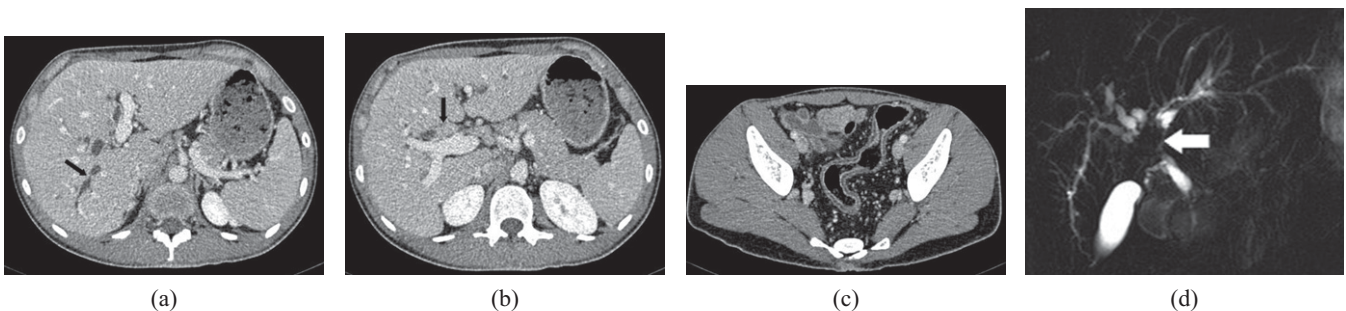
Axial CT images in a 35-year-old patient with longstanding ulcerative colitis with new onset of jaundice. Note intrahepatic bile duct strictures with pre-stenotic dilatation on axial CT (a). Dominant bile duct stricture (black arrow) with significant irregular concentric mass-like thickening (b). This was confirmed to represent a cholangiocarcinoma on recent surgery. The large bowel shows features of long-standing colitis (c). Magnetic resonance cholangiopancreatography image shows the “beaded/pruned tree” appearance of the intra- and extrahepatic ducts owing to multiple, short segment strictures (white arrow) (d). Note the dominant stricture noted in the liver hilum corresponding to the CT abnormality.
